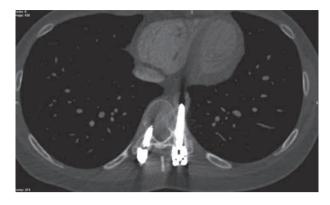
CT images of case 2 demonstrating a misplaced T10 left transpedicular screw, which penetrates the lateral cortex of the vertebral body and perforates the aorta.
